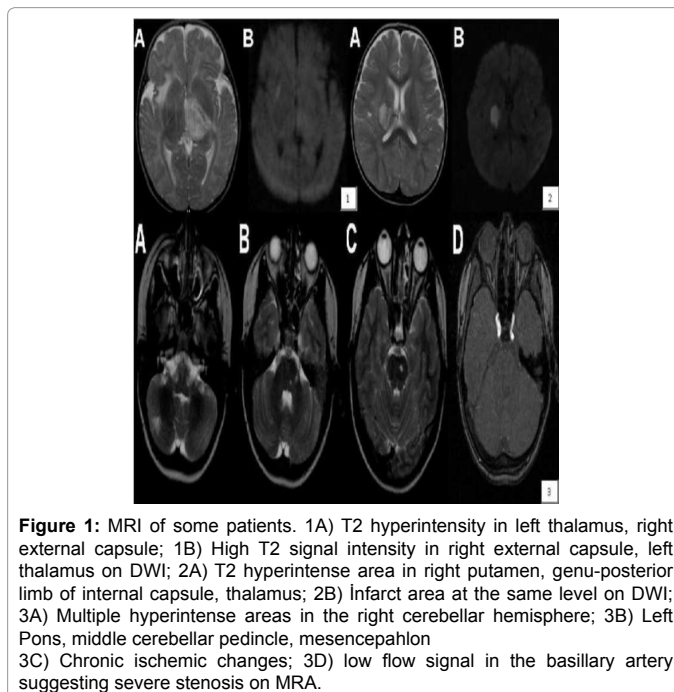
MRI of some patients. 1A) T2 hyperintensity in left thalamus, right external capsule; 1B) High T2 signal intensity in right external capsule, left thalamus on DWI; 2A) T2 hyperintense area in right putamen, genu-posterior limb of internal capsule, thalamus; 2B) Infarct area at the same level on DWI; 3A) Multiple hyperintense areas in the right cerebellar hemisphere; 3B) Left Pons, middle cerebellar peduncle, mesencephalon; 3C) Chronic ischemic changes; 3D) low flow signal in the basillary artery suggesting severe stenosis on MRA.
